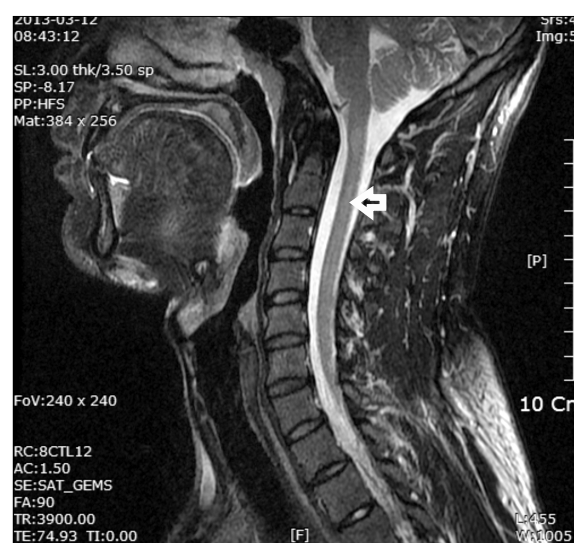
Marked improvement of previous intramedullary high signal intensity at cervical spinal cord, since last MRI.
